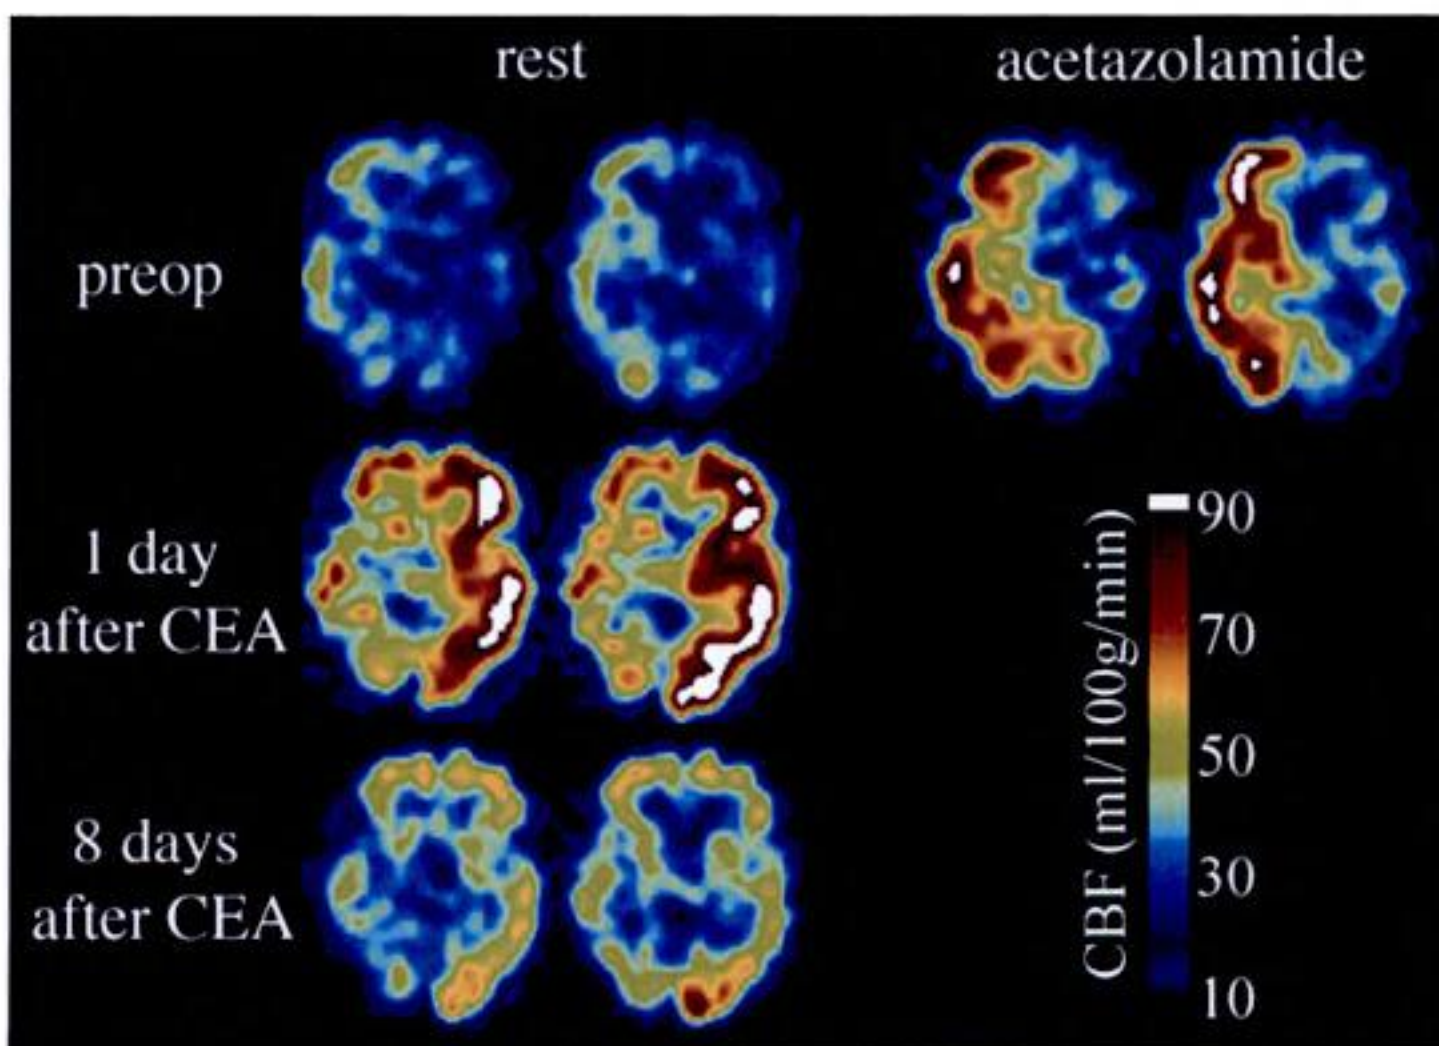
A case of hyperperfusion syndrome with severe left carotid stenosis after carotid endarterectomy. Top, preoperative SPECT. Severe hypoperfusion is seen in the left ICA territory on resting SPECT. Middle, SPECT on the first postoperative day clearly demonstrates hyperperfusion (>90 mL/min/100 gm, >100% increase of CBF) in the left ICA territory. Moderate CBF increase is also seen in the right ICA territory. Bottom, SPECT 8 days after carotid endarterectomy. Moderate CBF increase is still present in the left ICA territory. Rainbow displaying CBF from 10 to 90 mL/min/100 gm appears on the right.
